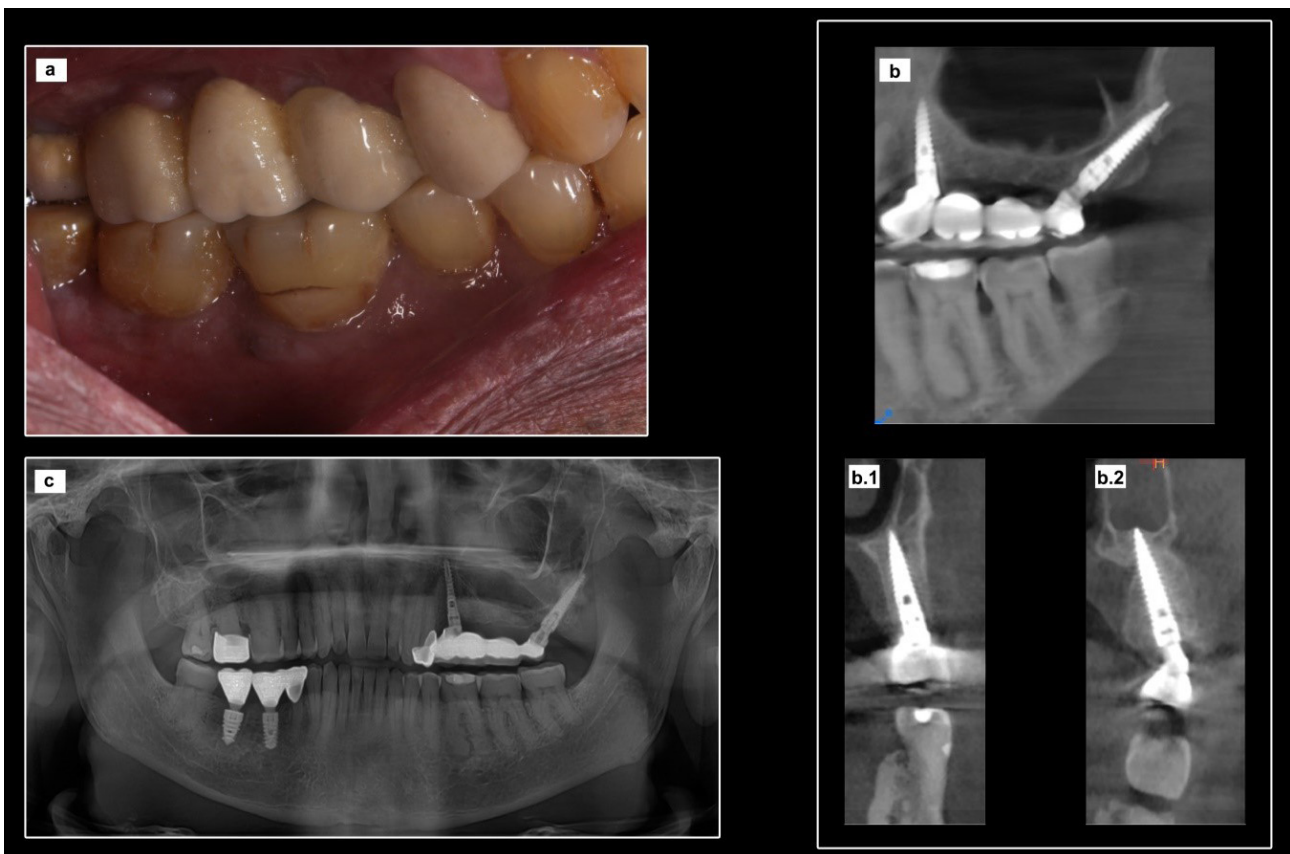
(a) Lateral view of 3 year follow up of prosthesis; (b) CBCT view of 3 year follow up of prosthesis in the region of 25 (b.1) and pterygoid region (b.2); (c) Panoramic view of 3 year follow up of the patient.
